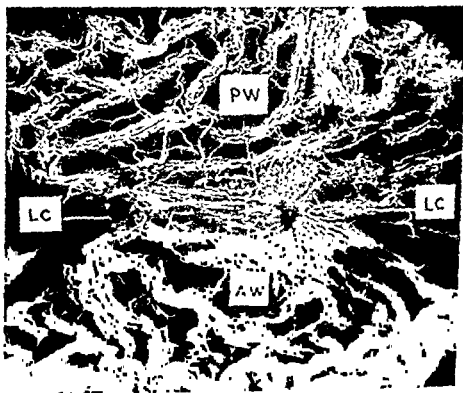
Radiograph of vessels of a stomach presenting an ulcer at the centre of a relatively avascular zone. The stomach and laid out flat. LC = Lesser curve and AW = Antrum (B) (courtesy of the Brit. med. J.) (\times 0.8.)
